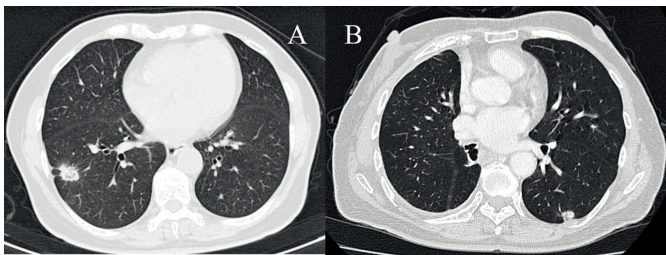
Chest CT findings of the first tumor of the right lung (A) and the second tumor of the left lung (B).
